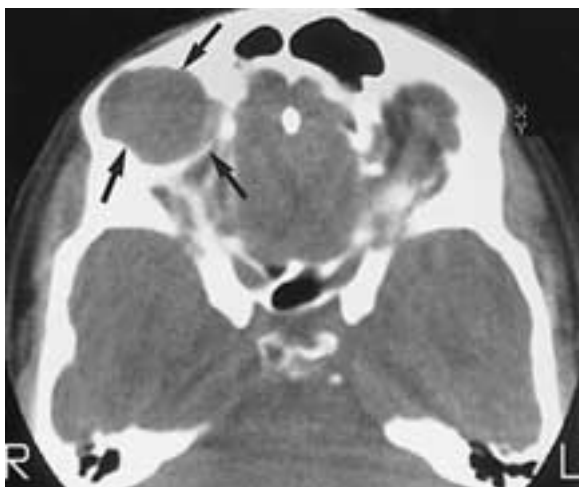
Chronic subperiosteal hematoma (cholesterol granuloma). Axial CT scan shows an expansile mass (arrows) compatible with a chronic hematic cyst. (From Dobben GD et al. Orbital subperiosteal hematoma, cholesterol granuloma, and infection. Evaluation with MR imaging and CT. Radiol Clin North Am 1998;36:1185–1200.)
